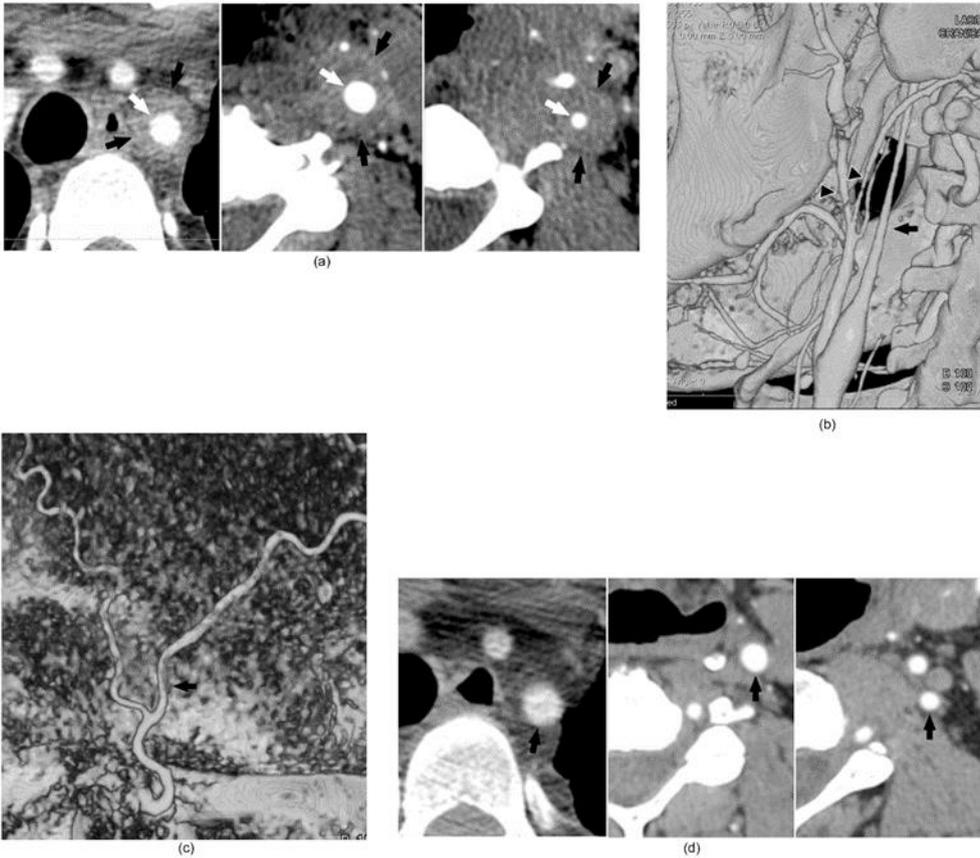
(a-d). Large vessel vasculitis with features of Takayasu arteritis and giant cell arteritis. (a) Marked mural thickening with heterogeneous enhancement within the bilateral cervical vasculature shown left to right: left subclavian, common carotid, and internal carotid arteries. The black arrows indicate the outer wall contour, normally a barely imperceptible margin, while the white arrows indicate the enhancing, narrowed vessel lumen with an appearance consistent with Takayasu arteritis. (b) CTA volume rendering with long segment smooth narrowing of the left internal carotid artery (black arrow) with more localized narrowing along the external carotid artery branches (arrowheads) typically found with giant cell arteritis. (c) CTA volume rendering narrowing of the superficial temporal artery (black arrow) as would be expected in giant cell arteritis. (d) Resolution of mural thickening within the left subclavian, common carotid and internal carotid arteries after treatment with corticosteroids. Abbreviations: CTA, computed tomographic angiography. Courtesy of Adam Davis, MD.
